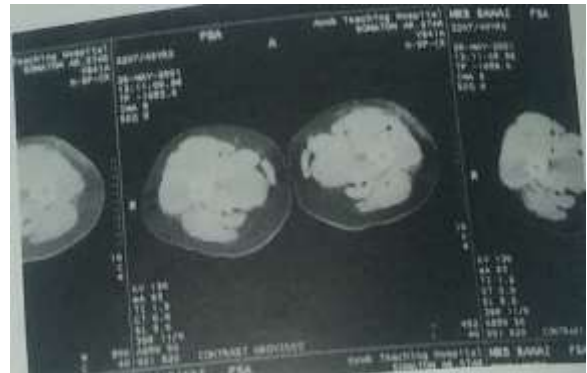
CT Scan Showing Soft tissue distortion (Case – II)
